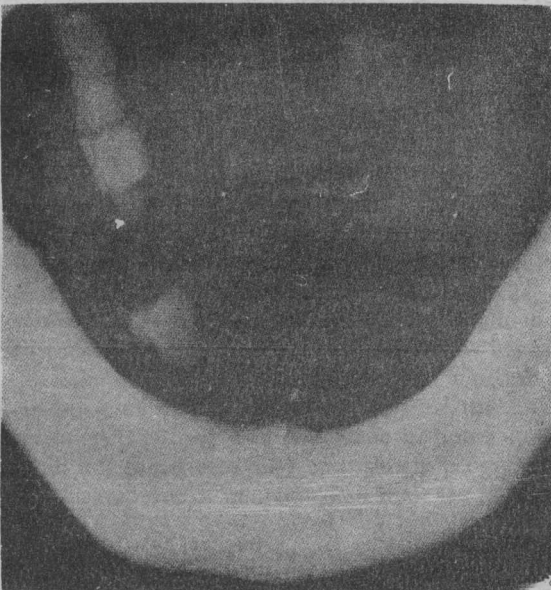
Plain x-ray: Intraoral view of floor of mouth, showing several radio-opaque stones in the submandibular duct near its orifice.
